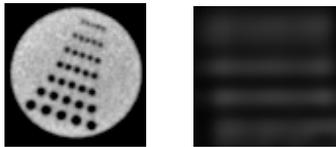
Details of a CT (left) and zoomed MRI image (right) showing the spots used for computing the high contrast spatial resolution. In the case of the MRI image the spots are not distinguishable.
